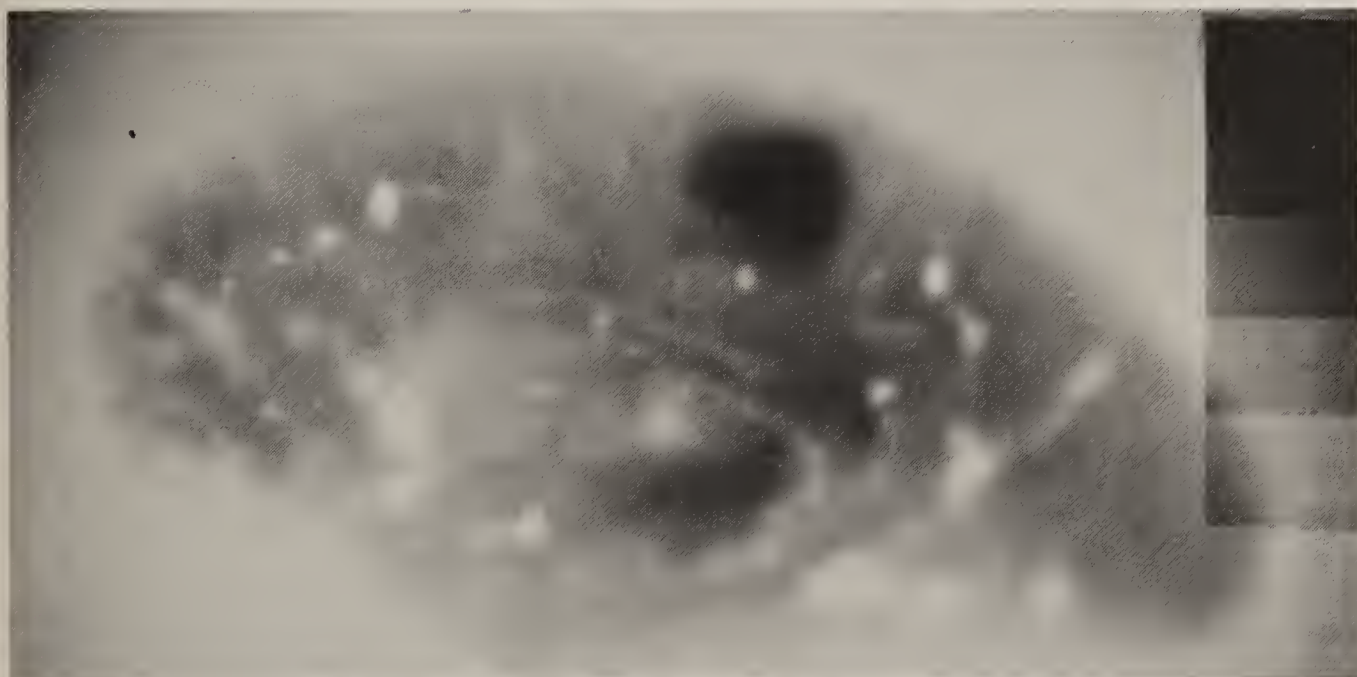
Proton radiograph of the hemisphere (positive). The conditions were 115 cm focus to film, no screen, Polaroid TLX film, and a dose to the first surface of approximately 290 rad in 0.8 minute.
